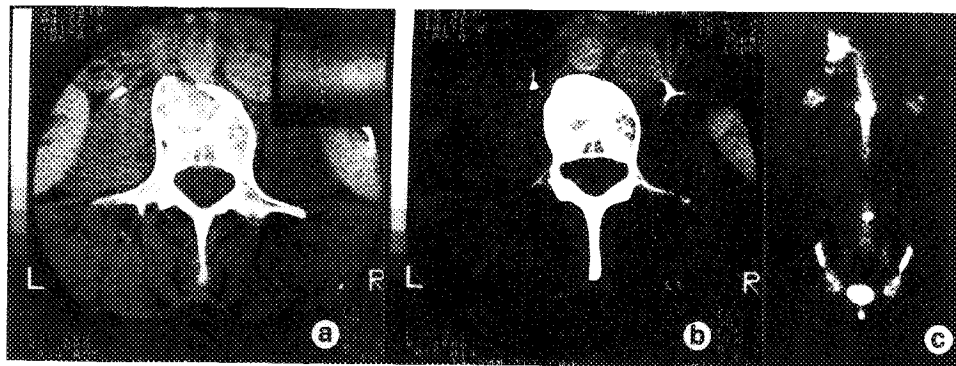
(a, b) CT scan at L<sub>3</sub> and (c) total body scintigraphy. See description in text.
